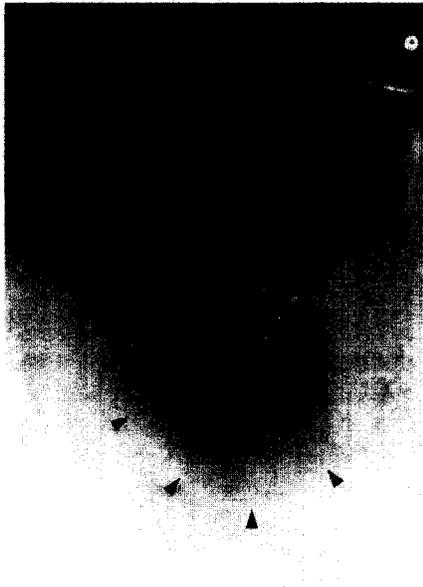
A periapical radiograph demonstrating periapical radiolucency surrounding the root of left mandibular lateral incisor (arrowheads).
